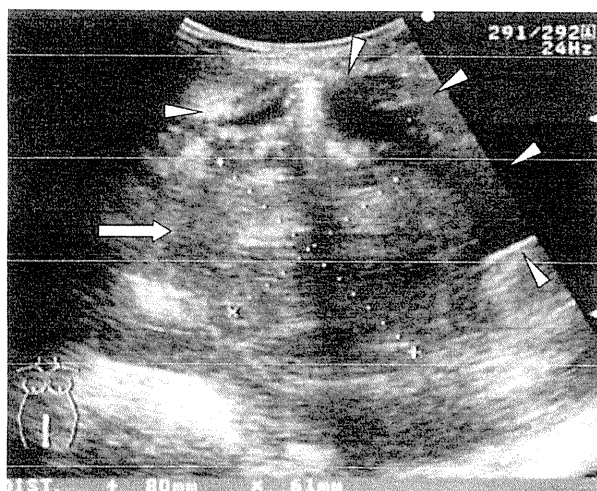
Ultrasonogram on admission. A hematoma was detected between the lower uterine segment and bladder (arrow). The bladder is indicated by arrowheads.
